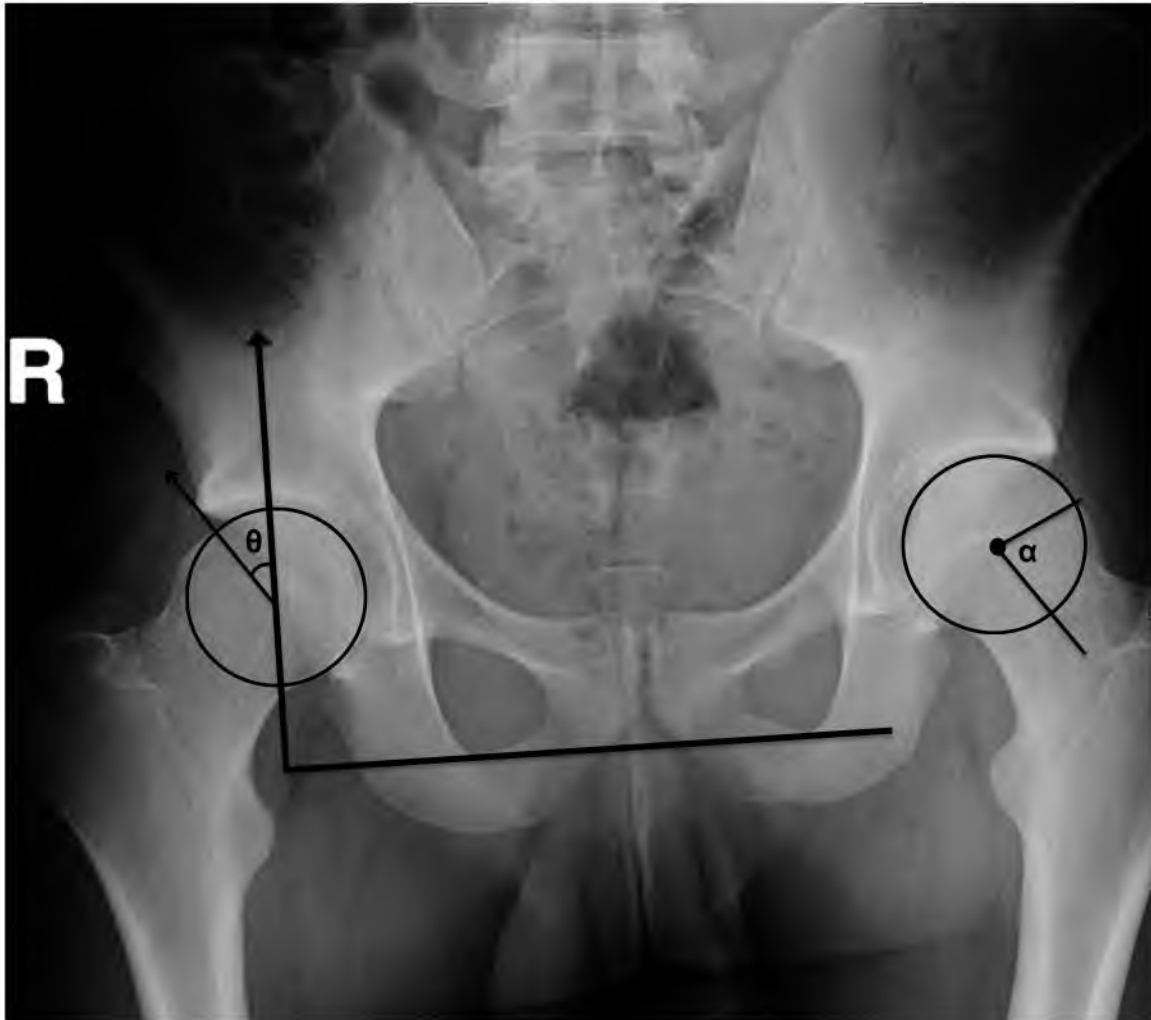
Two common radiographic measures of acetabular dysplasia and FAI. The lateral center edge angle (θ) is used for patients suspected to have dysplasia and measures the lateral coverage of the acetabulum over the femur. The alpha angle (α) is used to measure where a femur deviates from a circle fit to the femoral head and is used to diagnose cam FAI. Radiographic measures are useful for fast clinical screening but cannot fully describe the 3D deformities of dysplastic and FAI hips.
